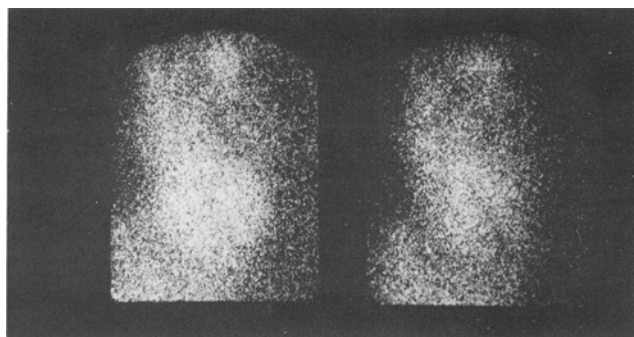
End-diastolic (left) and end-systolic (right) scintigrams of heart from LAO position.
